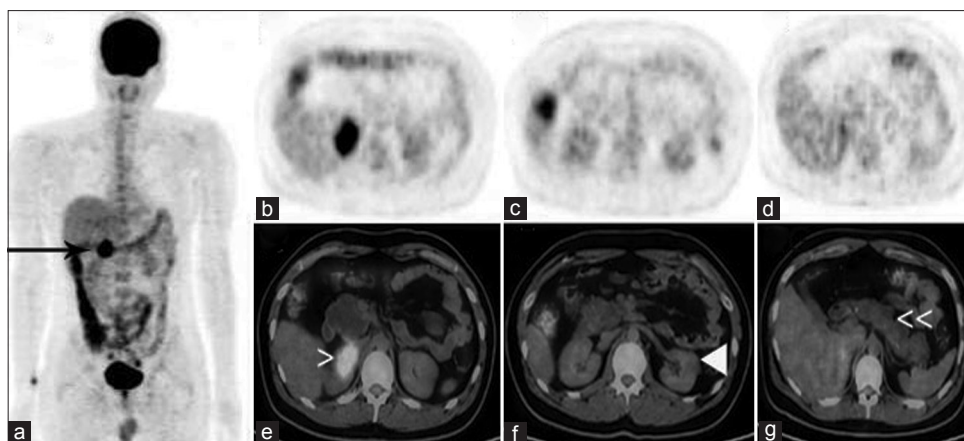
Maximum intensity projection image (a) shows avid FDG uptake in the right suprarenal region; (e) fusion image; shows localization to the right adrenal gland (>); another section; (f) shows amebiotic lesion in the lateral cortex of left kidney; (g) the entire pancreas; shows amebiotic cystic degeneration (<<)
